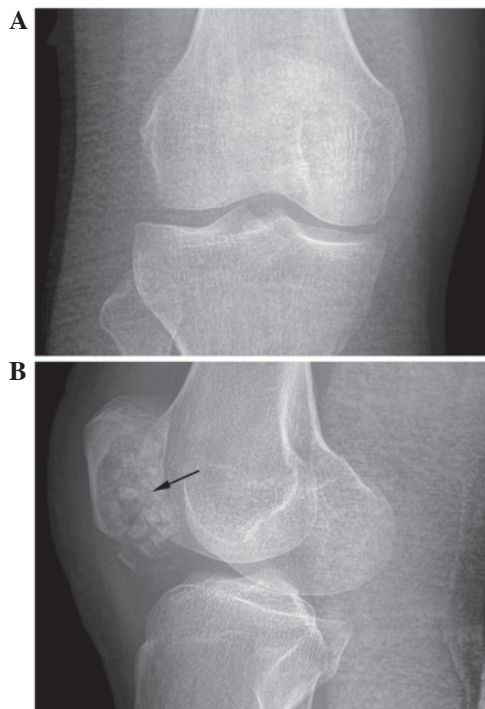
Postoperative plain radiograph. (A) No distinct change was observed on the frontal radiograph, while (B) the lateral radiograph showed that the cystic cavity had been filled with bone chips (arrow).
